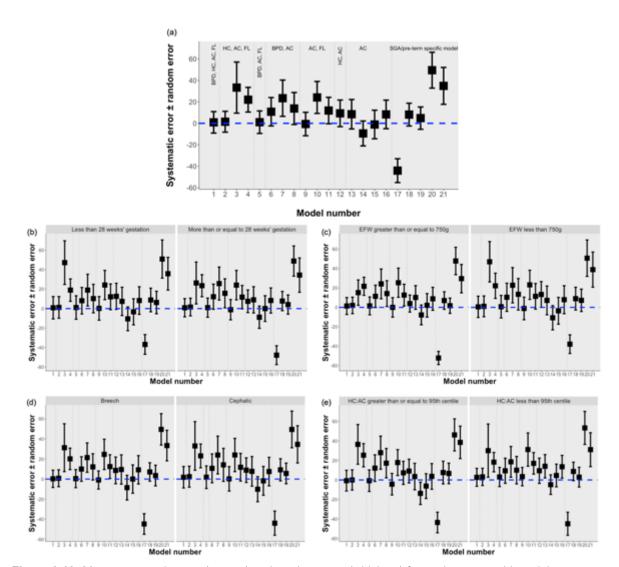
Mean systematic error (square) and random error (whiskers) for each sonographic weight estimation model investigated. The blue line represents a systematic error of 0; models plotting above the line show overestimation, models plotting below this line show underestimation of the fetal weight. (a) Entire cohort; (b) Cohort split by gestational age at scan (pre/post 28 weeks' gestation); (c) Cohort split by estimated fetal weight at scan (above/below 750g); (d) Cohort split by fetal presentation at scan; (e) Cohort split by symmetrical/asymmetrical FGR.
